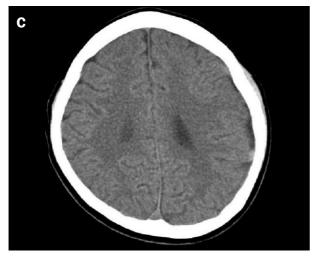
(A) Axial computed tomography (CT) of the brain reveals acute subdural hemorrhage (SDH) over the left frontotemporoparietal region with slight mass effect. (B) After 2 weeks, CT scan reveals left temporoparietal subdural effusion with increased thickness but decreased density. (C) After a further 1 month, axial CT of the brain reveals nearly no subdural effusion.
